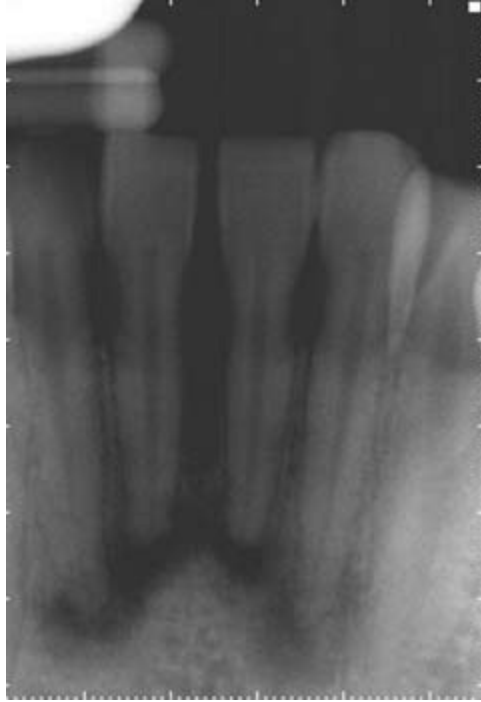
Multiple well-defined radiolucencies in the anterior mandible. The patient reported no history of trauma and was asymptomatic. These teeth had no significant dental history and responded to both cold and electric pulp testing. Based on this clinical presentation, a diagnosis of periapical cemento-osseous dysplasia was made and no treatment was indicated.
